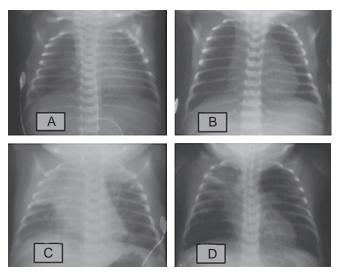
Chest radiographs from a premature infant who suffered RSV pneumonia early in life. A, This infant presented with neonatal respiratory distress syndrome (RDS) requiring mechanical ventilation; the radiograph shows a ground-glass appearance and lung volume loss from RDS on the day of birth. B, By 1 week of life, mechanical ventilation is discontinued and the lung fields normalize. C, At 6 weeks of life, the infant presented with an RSV-positive test and respiratory distress requiring mechanical ventilation; the radiograph shows diffuse interstitial infiltrates and atelectasis or pneumonia of the right upper lobe. D, By 7 weeks of life, the infant remained on a mechanical ventilator, but infiltrates and atelectasis were improving. (Radiographs courtesy of James Crowe, MD, Texas Children's Hospital.)
